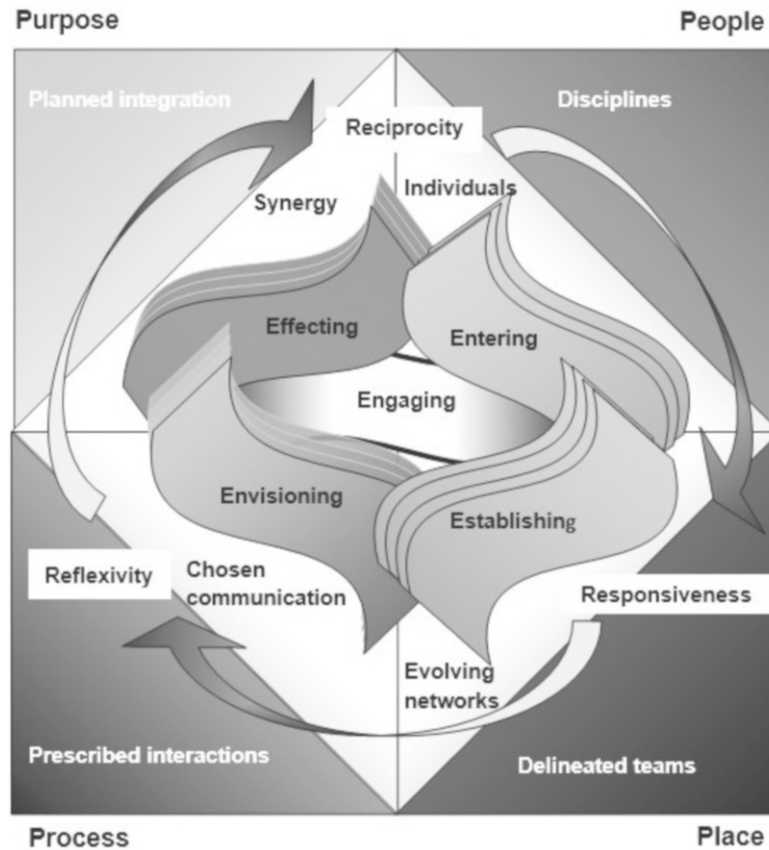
The RESPECT Model of Collaboration
